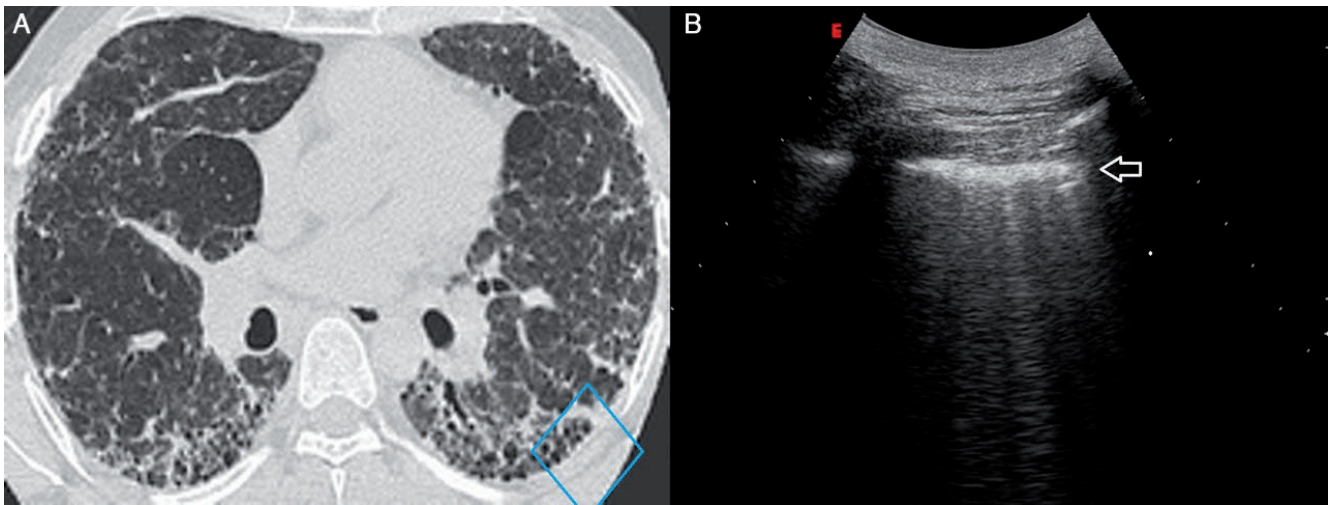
A) High-resolution computed tomography (HRCT) systemic sclerosis fibrosis pattern (peribronchiolar fibrosis, reticular-nodular and initial honeycombing). B) Transthoracic ultrasound scan, corresponding blue box in HRCT: thickness (5 mm) hyperechoic pleural line (white arrow) and *B line* below it.
